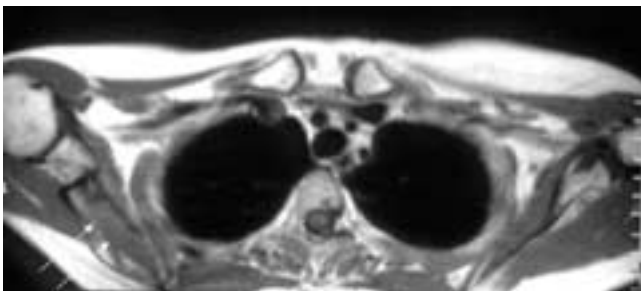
Metastatic breast carcinoma—right scapula. T1-weighted axilla MR image shows a decrease in the marrow signal (arrows) in the right scapula.
